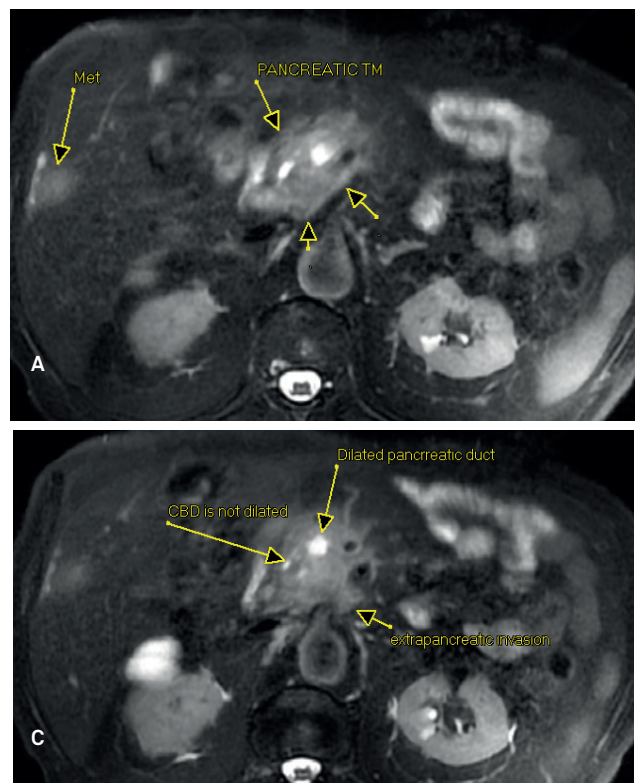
CE MRI of upper abdomen axial plane (a, b): There is tumoral mass lesion located in pancreatic head-body junction level, T2-hyperintense masses lesion in posterior inferior segment of right liver lobe and caudate lobe in lateral segment of liver lobe—metastasis. Pancreatic duct is totally obstructed at pancreatic head level with marked distal dilatation. CBD is coursing just lateral mass lesion and there is no remarkable invasion at this stage. There is extra pancreatic invasion involving superior mesenteric arterial root.
